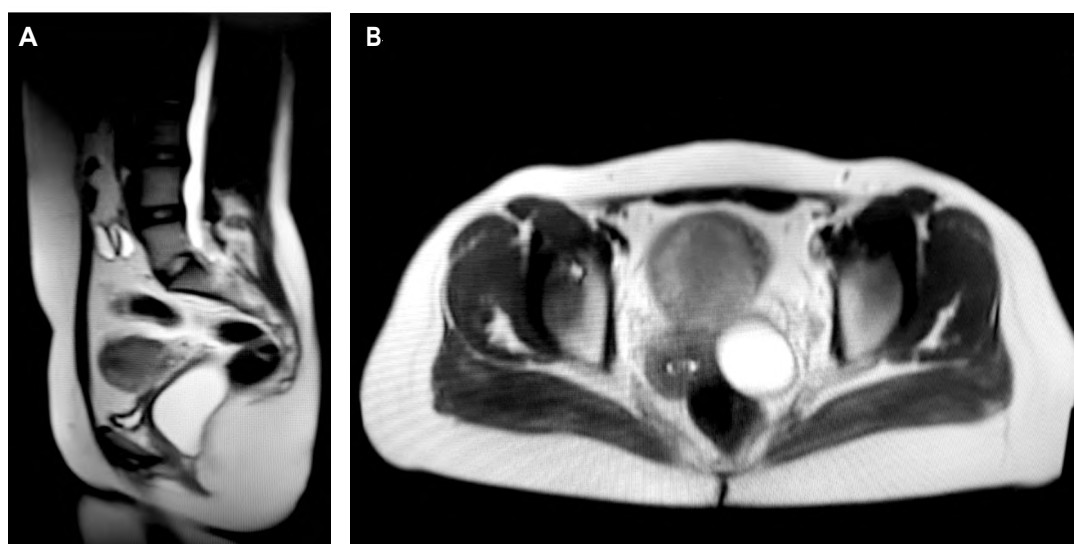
MRI saggital (A) and axial (B) Planes showing an elongated cystic structure in the recto-vaginal space slightly to the left side.
